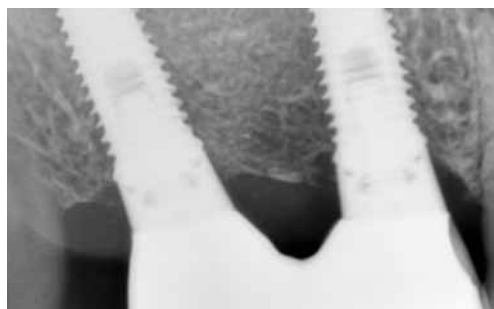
A periapical x-ray at the delivery of a definitive prosthesis (2 unit PFM SCRP) 4 months after the surgery.
